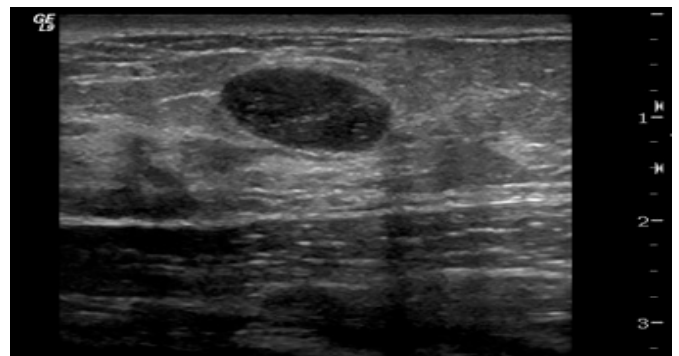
Sonogram of a breast having a fluid filled cyst
